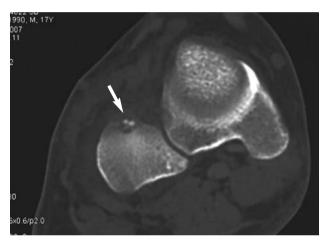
CT scan of the right foot. Note the subperiostal lesion in the cuboid (arrow).
